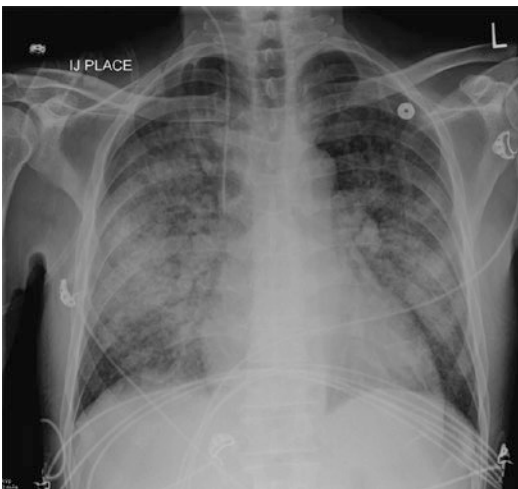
Chest x-ray on post-admission day 2 showing severe pulmonary edema
